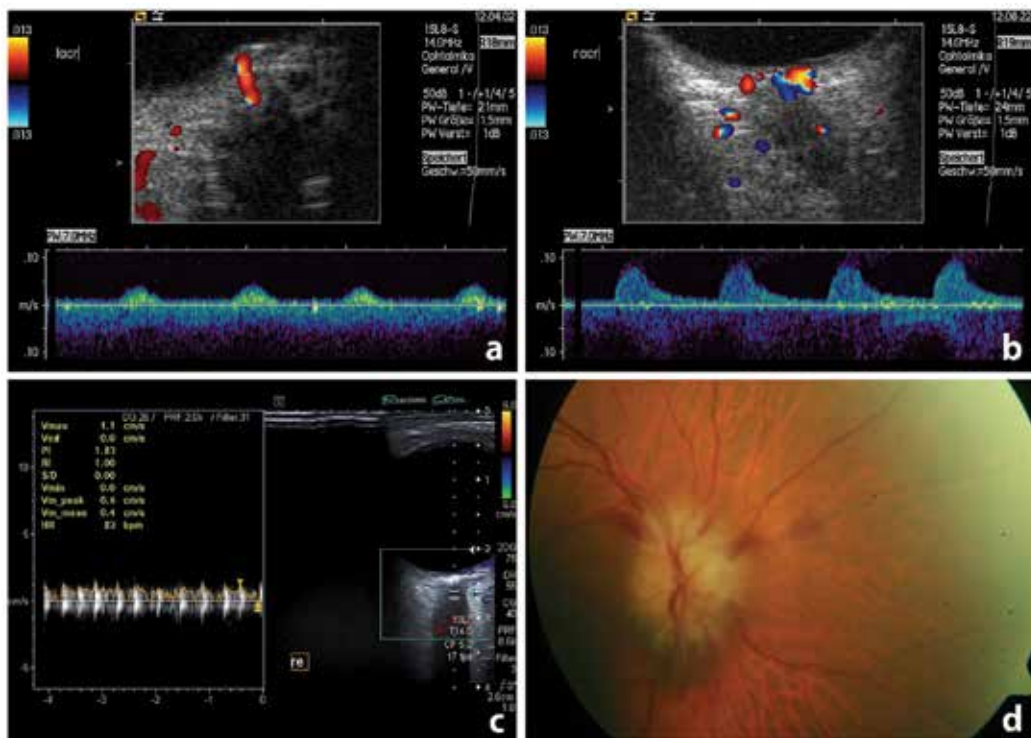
Ultrasound and fundoscopic findings in patients with central retinal artery occlusion due to temporal arteritis. (a) Patient 1: Color-Duplex- and spectral Doppler-mode: Pseudovenous flow in the affected CRA. (b) Patient 1: Color-Duplex- and spectral Doppler-mode: normal flow in the unaffected contralateral CRA. (c) Patient 2: Color-Duplex- and spectral Doppler-mode: zero-flow in the affected CRA. (d) Patient 2: funduscopy: blurred rim of optic disc, optic disc edema and hyperemia, small splinter hemorrhage
